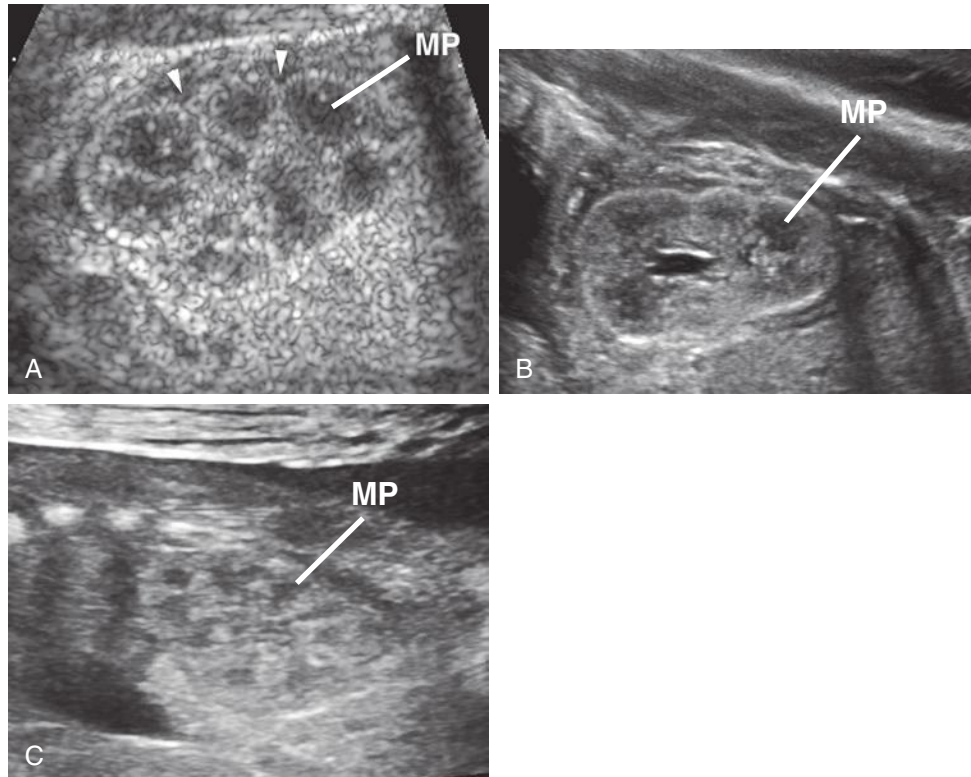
A, Longitudinal sonogram through the early second trimester fetal kidney (*arrowheads*). B, Longitudinal sonogram through a late second trimester fetal kidney. Note that the medullae (MP) appear more prominent earlier. This is because cortical growth is greater than that of medullary growth, and thus the relative size of the medullae decreases. C, Longitudinal sonogram through a third trimester fetal kidney. Among the normal variations of fetal renal appearances, note that the renal echogenicity can be relatively increased because the cortical tissue is echogenic, thus better outlining the more echolucent medullary pyramids (MP).
